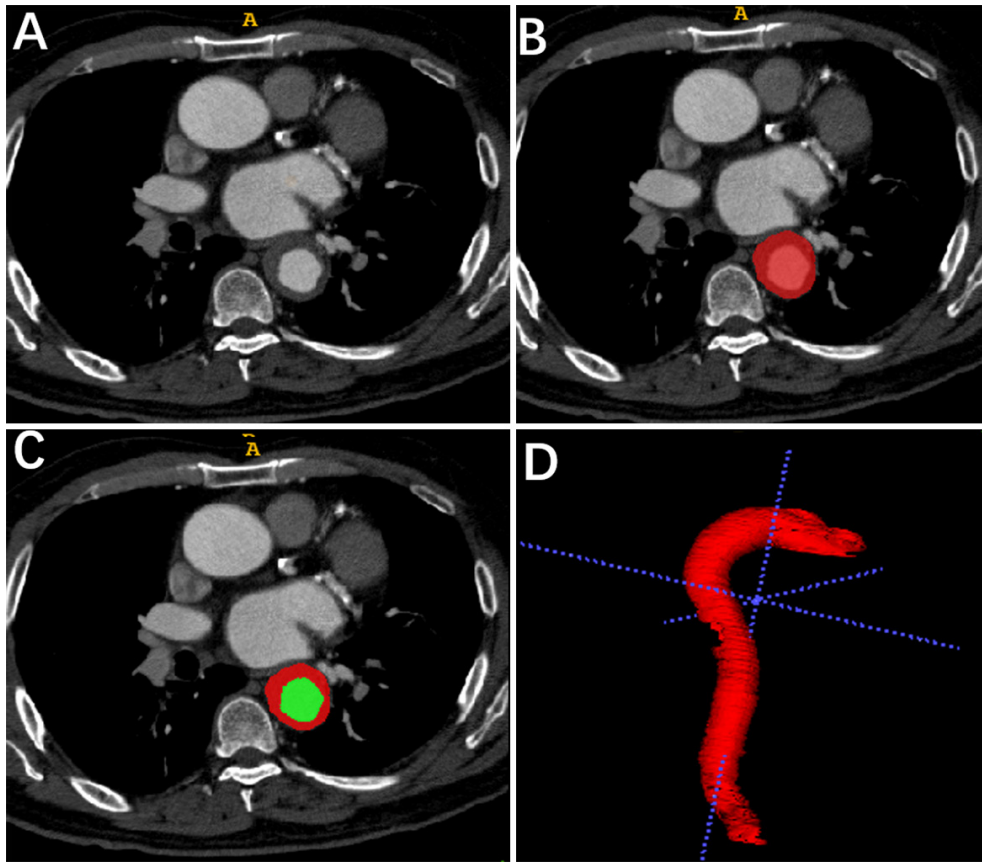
The computed tomography angiography of a patient with aortic intramural hematoma patient (A). The aorta and the hematoma were labeled as Label1 (B; red). The aortic lumen was covered by Label2 based on Label1 (C; green). The overlap area of Label1 and Label2 was removed, and only the hematoma outside the aortic lumen was preserved. The 3D reconstruction of an intramural hematoma (D).
